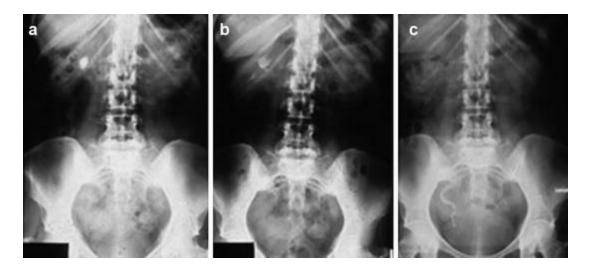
Patient X-ray follow-up (a) before (b) immediately after shockwave exposure. (c) Steinstrasse in distal ureter
